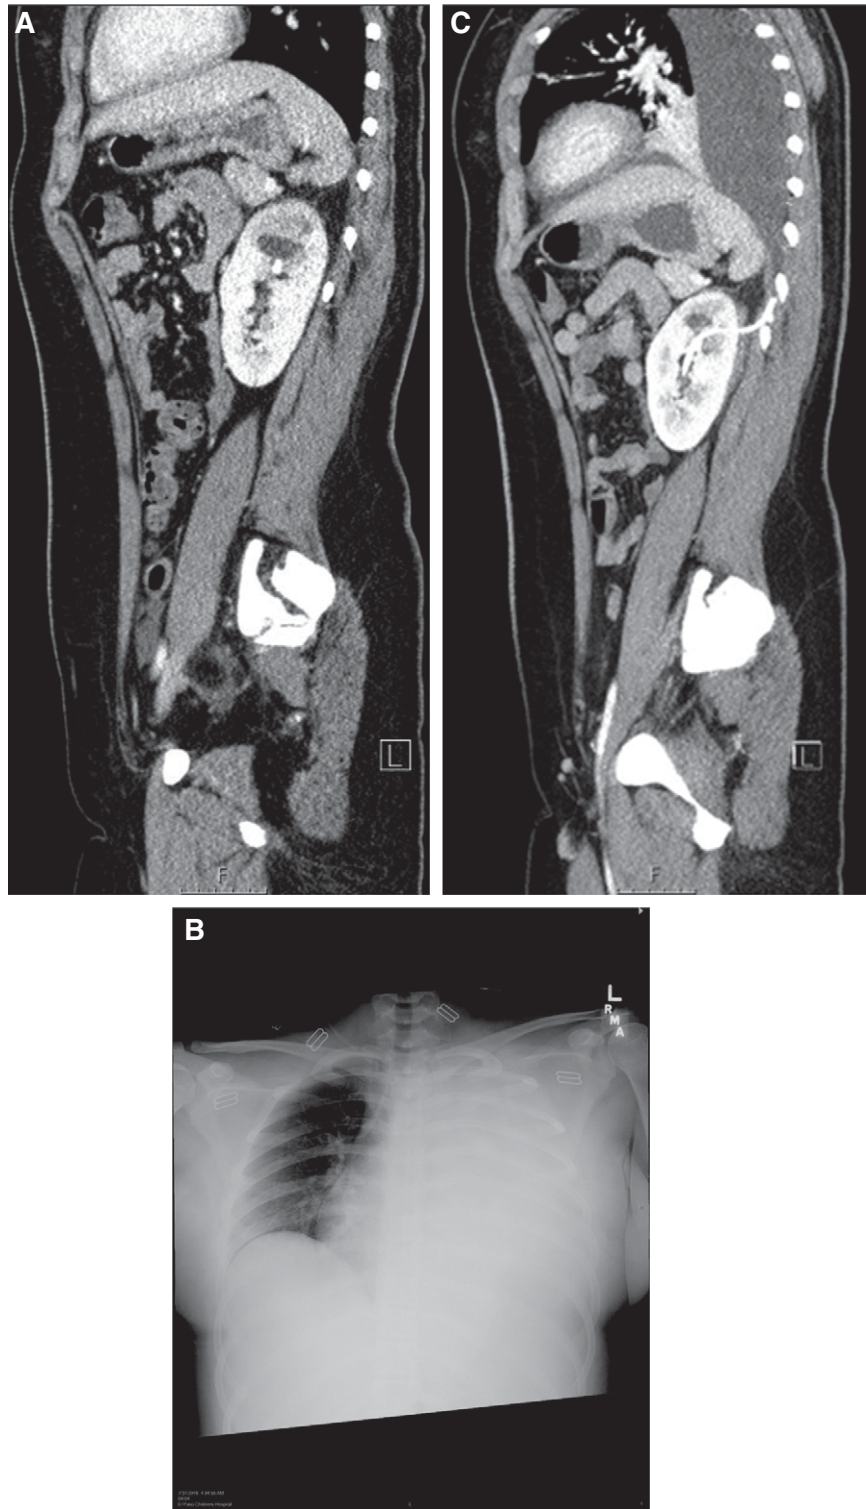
Computed tomography (CT) scan of abdomen and pelvis. A CT scan of the abdomen and pelvis demonstrates a stone in the left upper pole of the kidney with associated pyelonephritis (A). On postoperation day 4, after left nephrostomy tube placement, the patient developed shortness of breath and her left chest pain increased in intensity to 10 out of 10, with dullness on percussion. (B) Chest roentgenogram (x-ray) demonstrates a large left pleural effusion on postoperation day 4. Ultrasound guided diagnostic pleurocentesis and left chest tube placement were done. The pleural fluid creatinine was 6.8 mg/dl and pleural fluid to serum creatinine ratio was 6.8, with pleural fluid lactate dehydrogenase of 316 IU/L. (C) CT scan of the abdomen and pelvis shows a percutaneous nephrostomy tube in the upper pole of the left kidney that is communicating with the pleural space with an associated pleural effusion.
